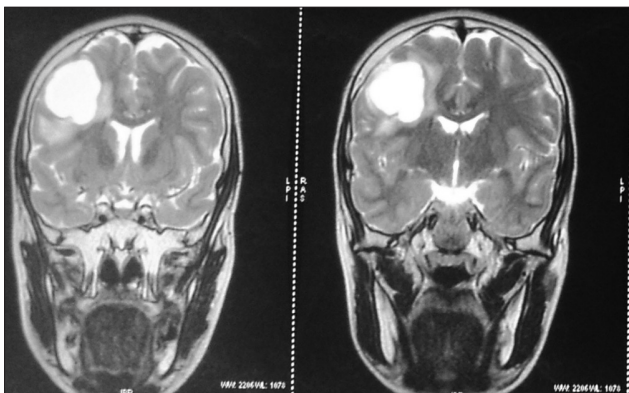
Magnetic resonance image (MRI) of the brain revealing a circumscribed right parietal lesion. The lesion was hypointense in T1 weighted image
